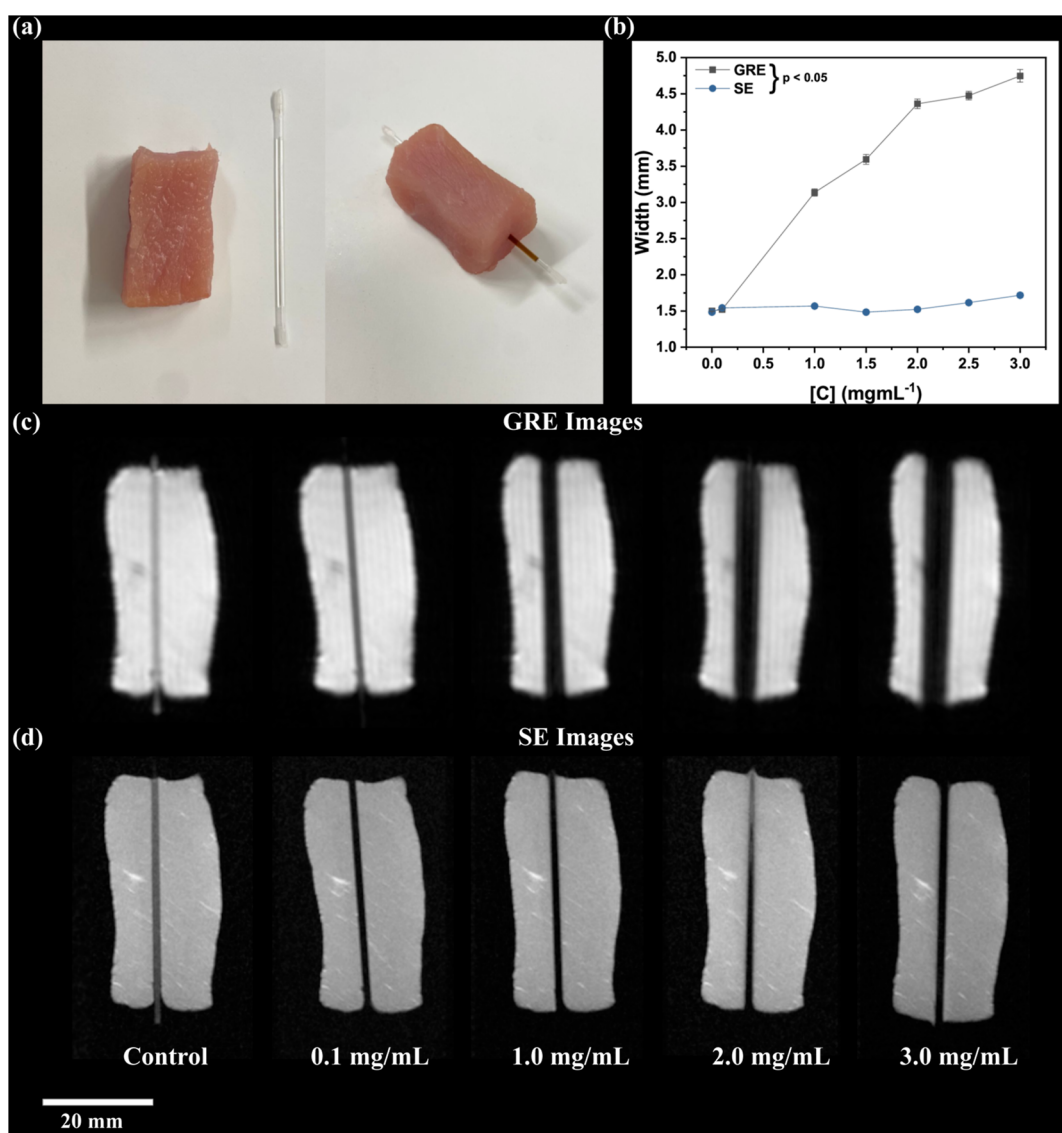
(a) Pork loin pieces with distinct capillaries containing water (control) and the magnetic NPs. (b) Width of the capillary estimated using the spin echo (SE) and gradient recalled echo (GRE) sequences for distinct NP concentration. (c) GRE and (d) SE magnetic resonance images for the capillary inserted pork loin filled with water (control) and different concentrations of NPs.
